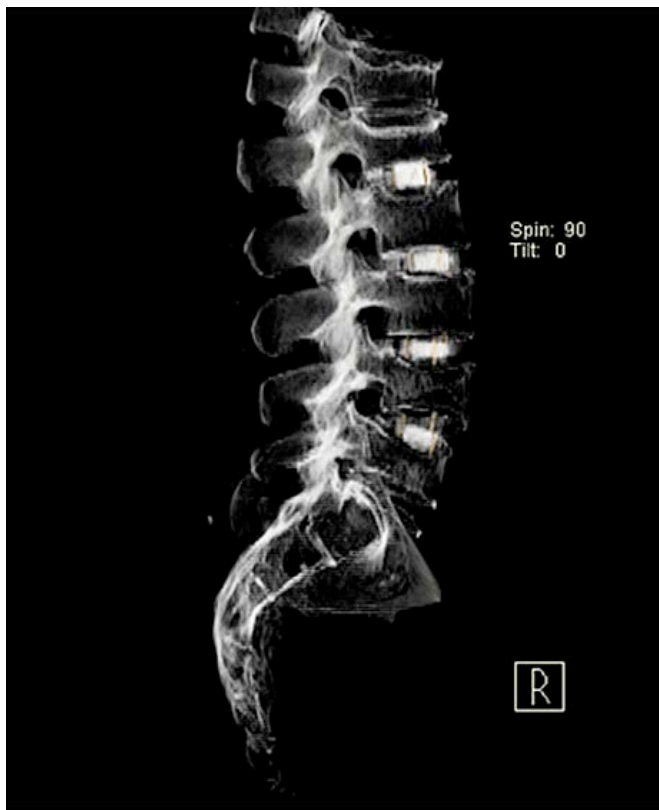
3-D CT-scan image of pre Infill injection of graft material.
